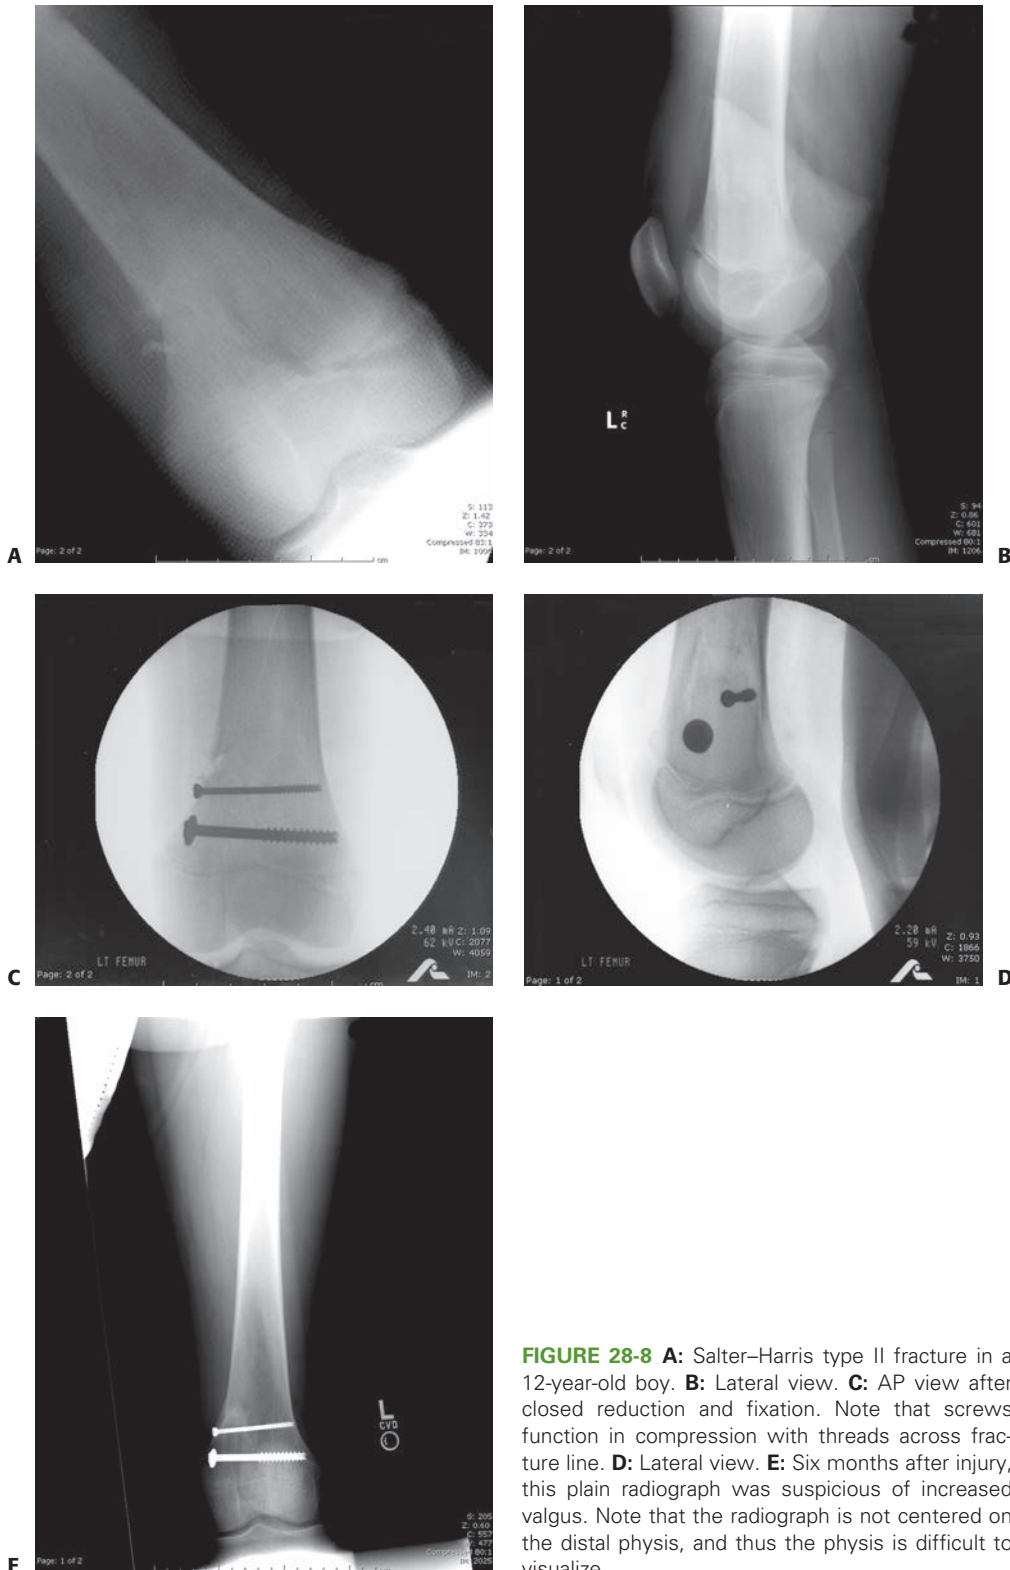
A: Salter–Harris type II fracture in a 12-year-old boy. B: Lateral view. C: AP view after closed reduction and fixation. Note that screws function in compression with threads across fracture line. D: Lateral view. E: Six months after injury, this plain radiograph is suspicious of increased valgus. Note that the radiograph is not centered on the distal physis, and thus the physis is difficult to visualize.
